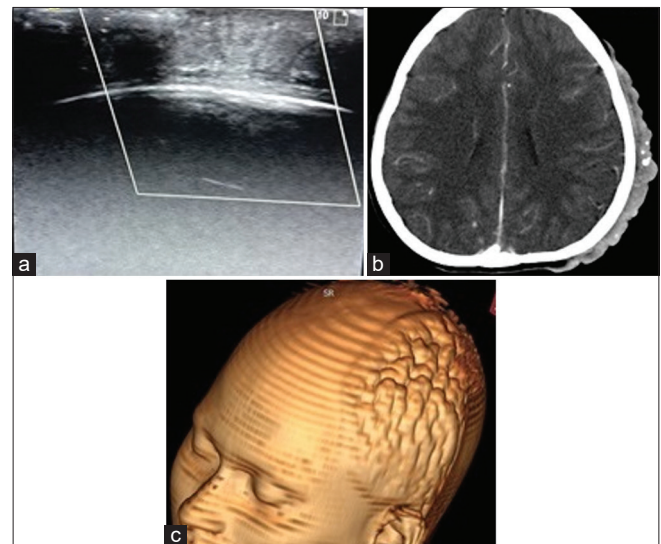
(a) Ultrasound examination of the scalp showing thickened skin and subcutaneous tissue with absence of color uptake thus ruling out underlying vascular malformation in a patient with cerebriform intradermal nevus. (b) Contrast-enhanced computed tomography of brain of the same patient showing non-enhancing circumscribed wavy scalp thickening with tiny specks of calcifications involving left parietal region with normal calvarium and brain parenchyma. (c) Contrast-enhanced computed tomography of brain with 3D surface rendering of the same patient showing non-enhancing circumscribed wavy scalp thickening with tiny specks of calcifications involving left parietal region with normal calvarium and brain parenchyma.
